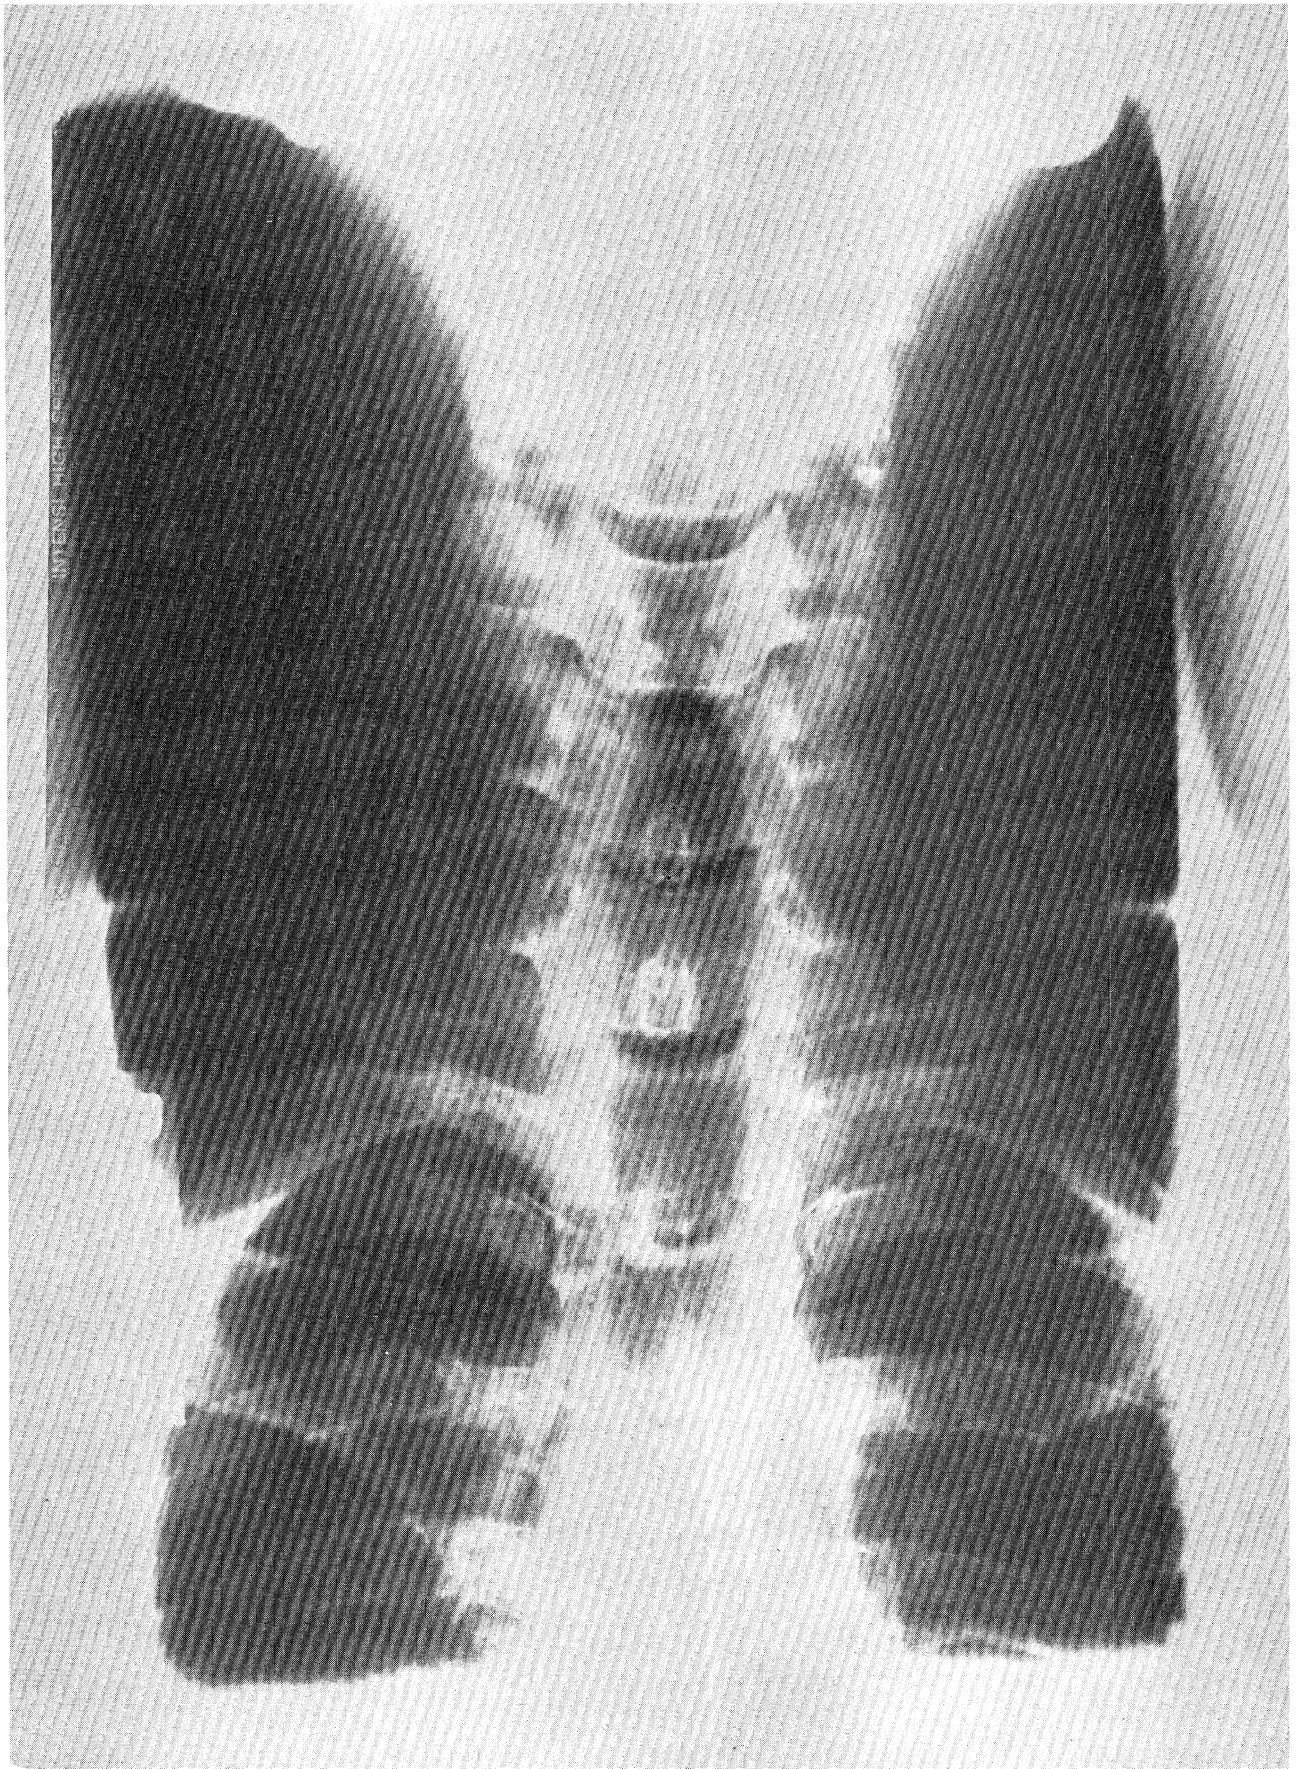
Cervical Radiograph, Anterior-Posterior View.
